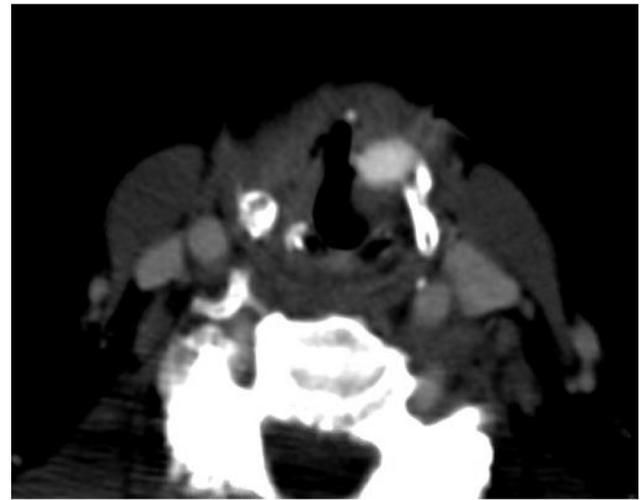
CT neck with IV contrast with left anterior paraglottic laryngocutaneous fistula communicating with left laryngeal Silastic implant (axial).
